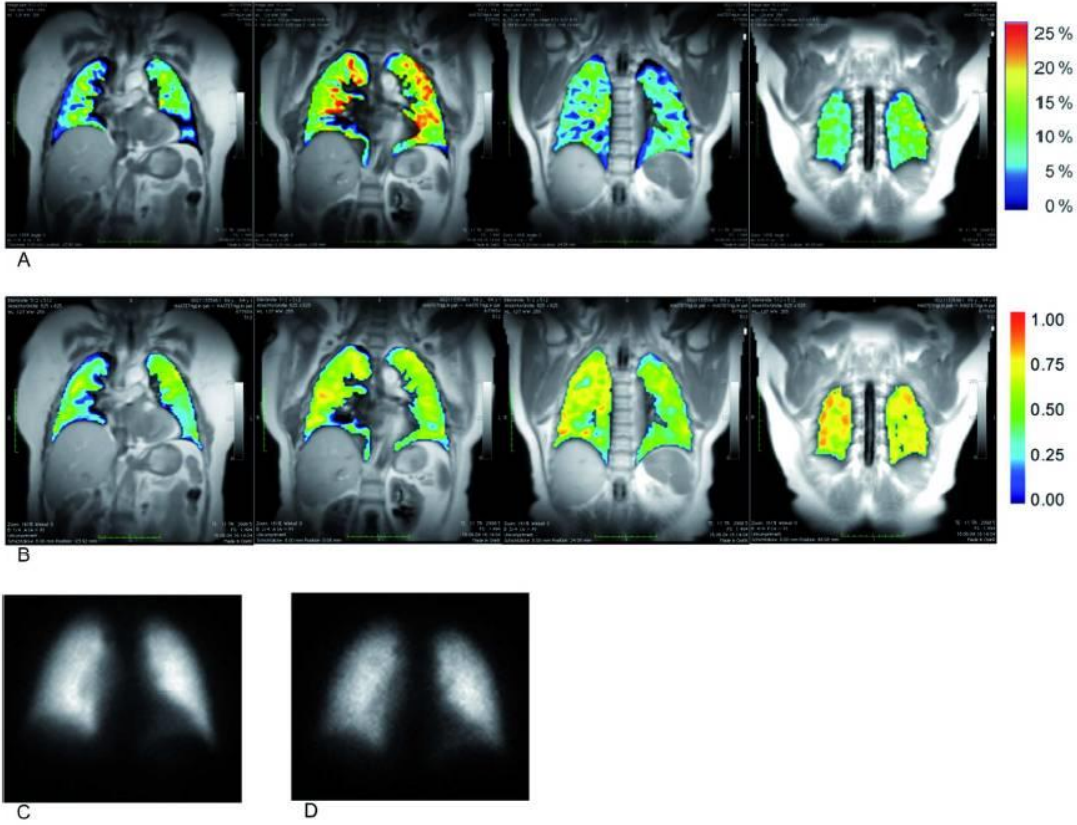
64-year-old female patient without circumscribed defects. A: RSE maps with relatively homogenous SI after oxygen inhalation. B: CCC maps without defects and with an overall more homogeneous SI if compared with the RSE maps. C: Ventilation scintigraphy with regular ventilation. D: Perfusion scintigraphy without detectable perfusion defects.
